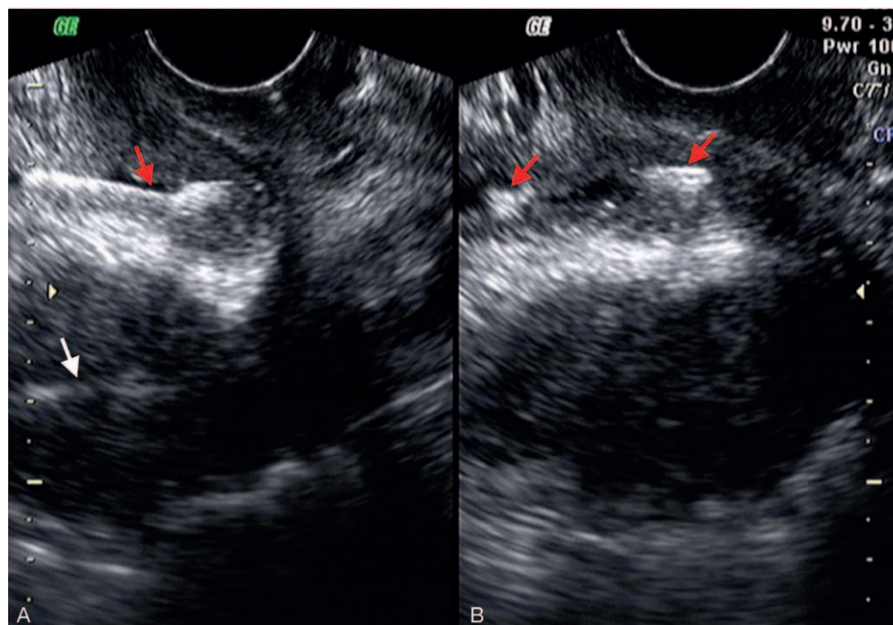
Ultrasound examination of the bladder and uterus. (A) US showing MCu intrauterine device (IUD) with a strong echo in the bladder (red arrow) and another IUD with a moderate echo in the uterus (white arrow). (B) US showing MCu IUD with strong echo (red arrows) in the bladder. IUD = intrauterine contraceptive device, US = ultrasonography.
